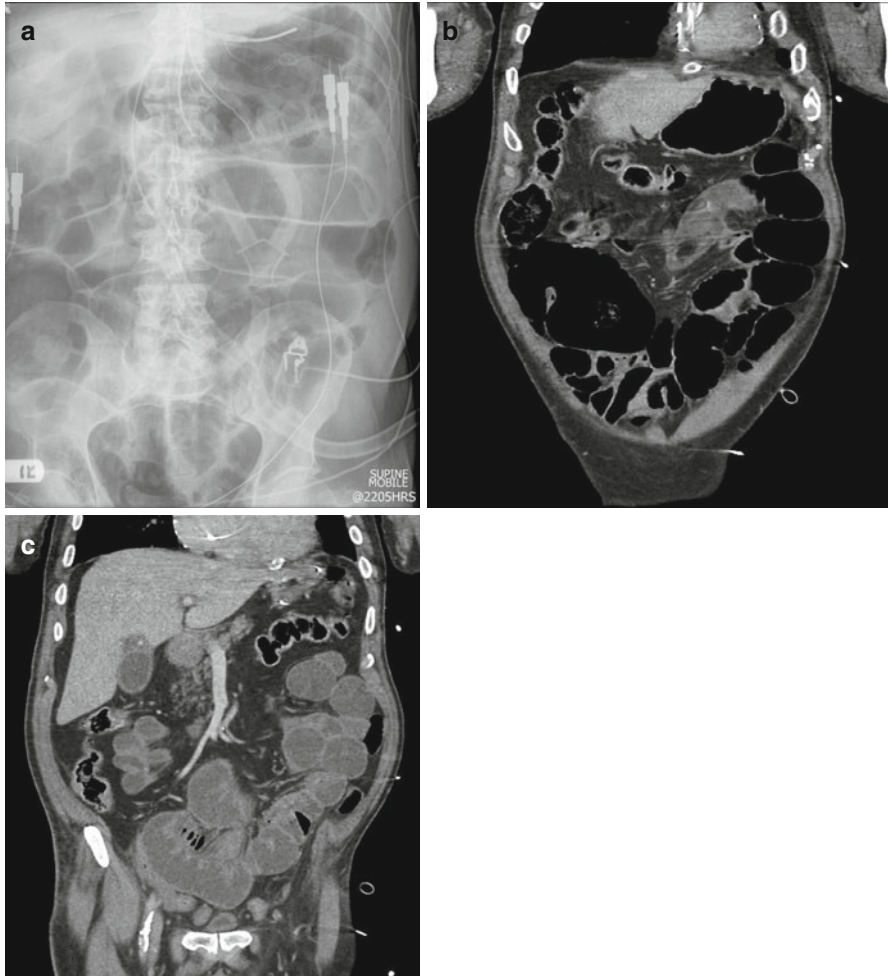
(a) Abdominal X-ray in a patient 2 days following cardiac surgery shows dilated gas filled small and large bowel loops. (b, c) CT during IV contrast medium administration shows dilated small bowel loops and caecum which are partly fluid and gas filled. There is no obstructive lesion and no abrupt transition point consistent with ileus, which resolved spontaneously
